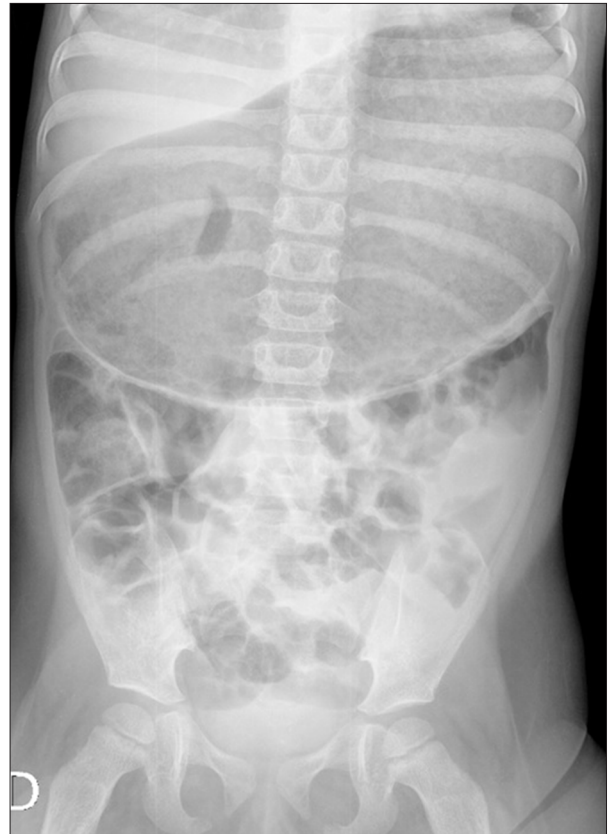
Abdominal x-ray with gastric dilatation.
